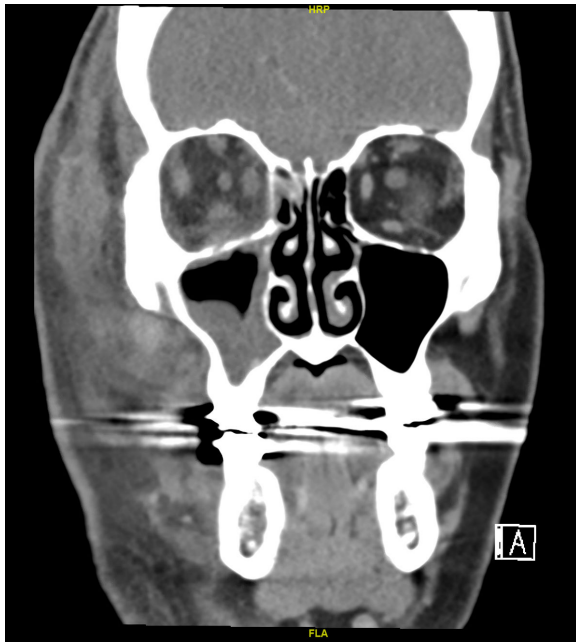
Coronal CT of the head and orbits, with contrast, showing edema of the right post septal orbit and maxillary sinus disease.
